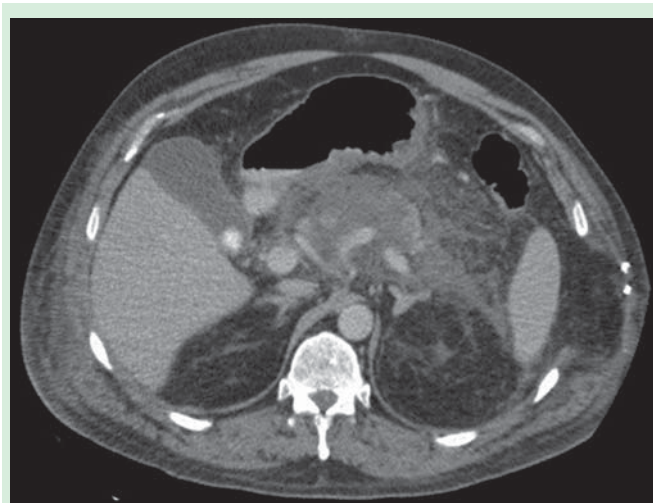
CT scan performed 6 days after admission demonstrating complete necrosis of the pancreas neck and body.
